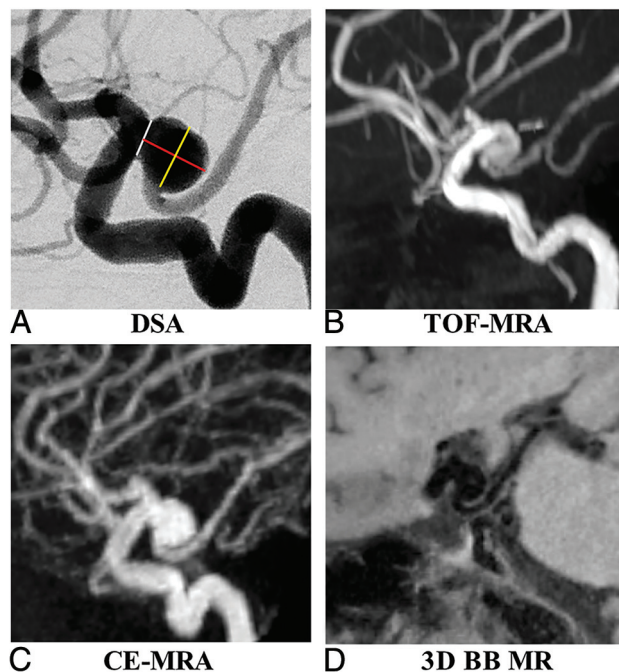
A 61-year-old woman with a right posterior communicating artery aneurysm on DSA (A), TOF-MRA (B), CE-MRA (C), and 3D-BB MR imaging (D). Aneurysm height (red line), width (yellow line), and neck (white line) measurements are demonstrated in A.
